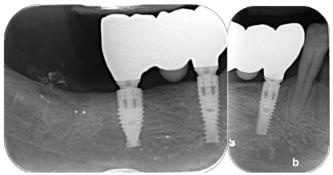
a. Clinical view after 3 years; b. Periapical X-Ray after 3 years.
